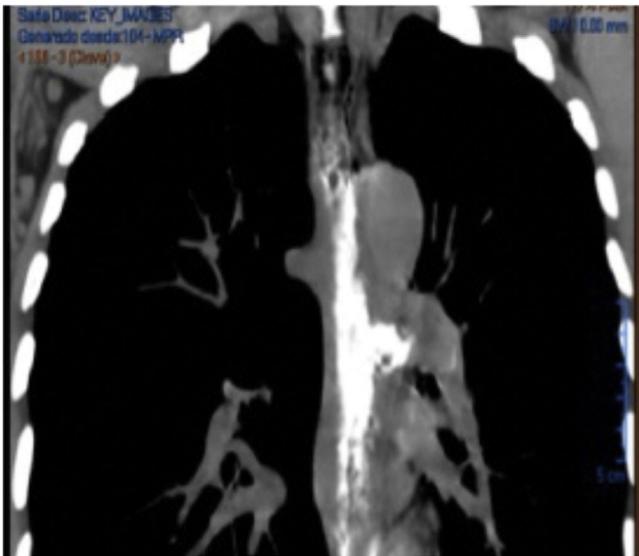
The chest computed tomography scan with contrast medium showing pneumomediastinum and contrast material leakage at the left lateral surface of the esophagus.
